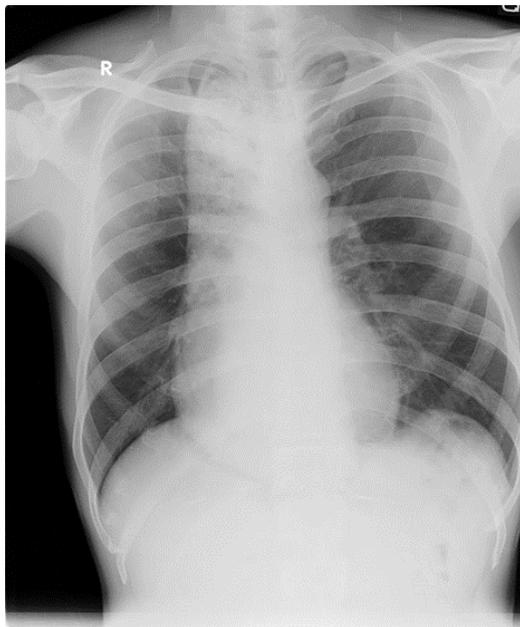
Classic appearance of achalasia on chest radiographs shows mediastinal widening, a trace amount of gastric air-bubble is seen.¹¹
